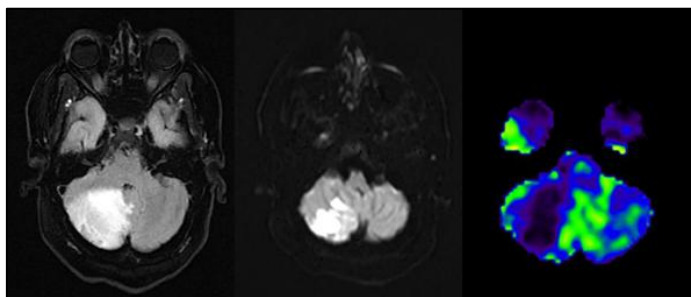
T2 / FLAIR, DWb1000, RGBCBF
